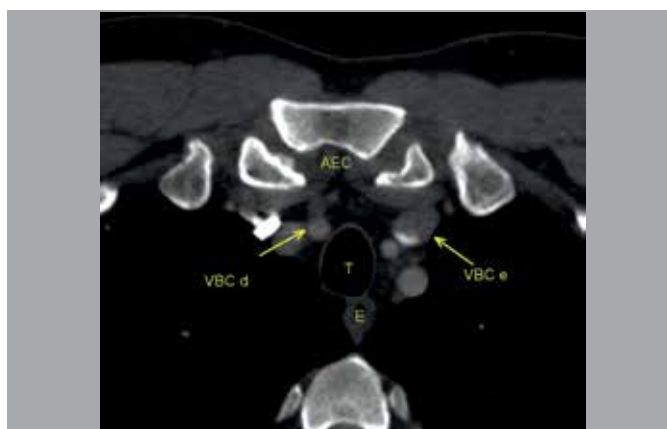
Axial computed tomography image demonstrating the hilar structures (AEC: sternoclavicular joints, VBC d: right brachiocephalic vein, VBC and: left brachiocephalic vein, T: trachea, E: esophagus).
